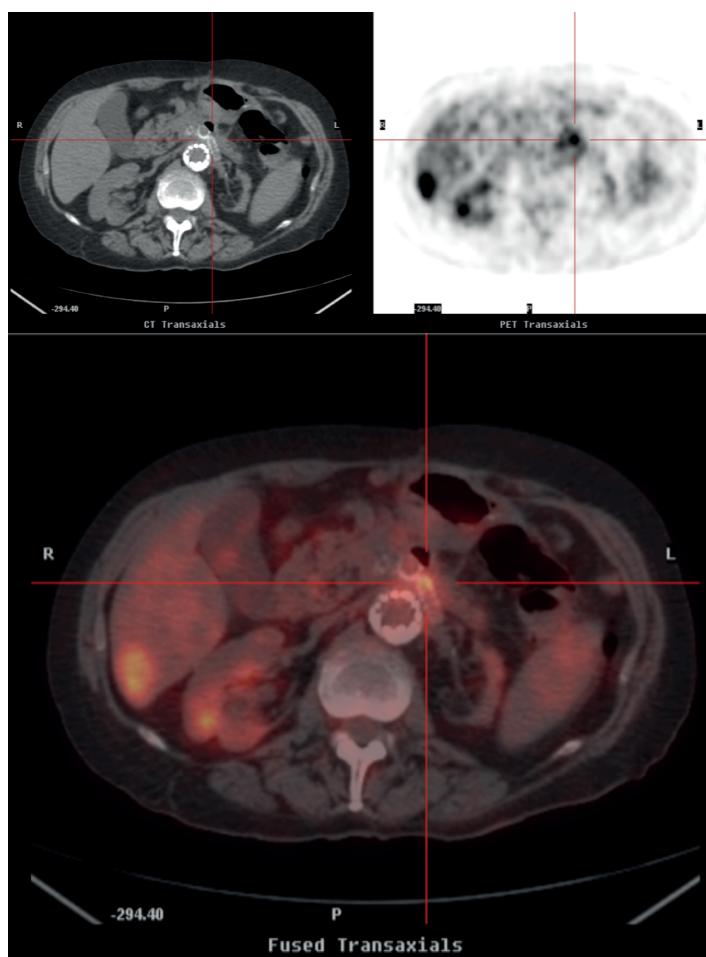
Example of attenuation CT, PET image, and fused images PET/CT. This examination revealed a vascular graft infection.
